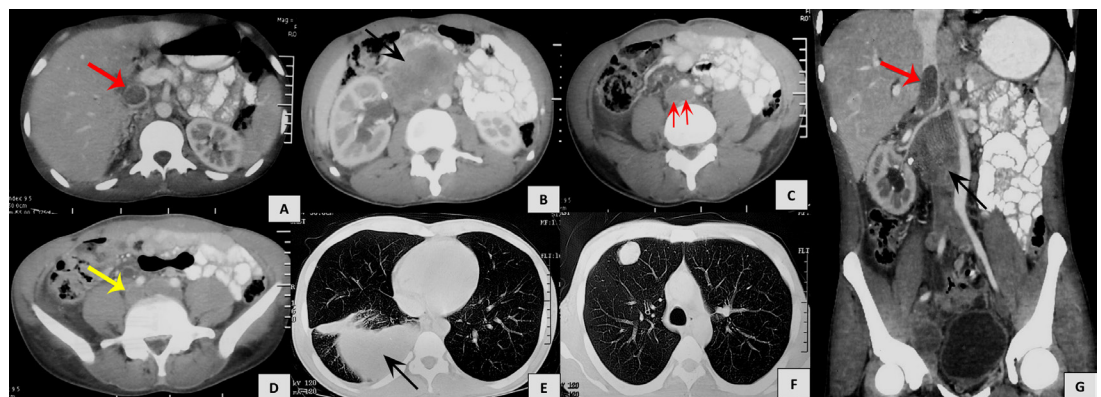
Contrast-enhanced CT scan. (A) Infrahepatic inferior vena cava (IVC) tumorous thrombosis (arrow) filling almost whole of the circumference. (B) Large heterogeneous enhancing retroperitoneal lymph nodal mass (arrow). (C) Bifurcation of IVC showing tumorous thrombosis (multiple arrows). (D) Tumour thrombosis extending up to bilateral common iliac veins (arrow), (E) showing hypodense opacity (arrow) in right lung lower lobe (collapse/consolidation) with minimal right pleural effusion, (F) showing pulmonary metastases. (G) Sagittal section showing IVC thrombosis (coloured arrow) with retroperitoneal lymph node mass (black arrow).
